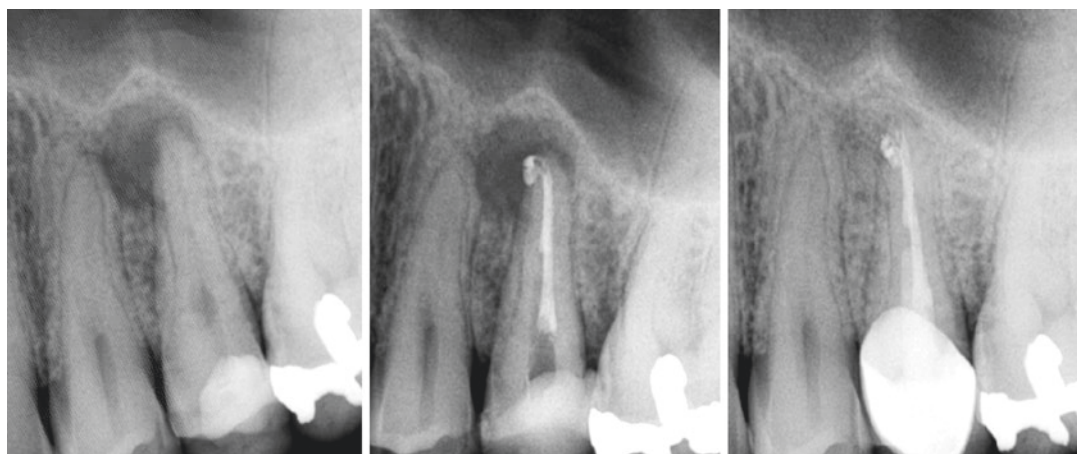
Second maxillary premolar—the patient presented with a sensitivity to percussion: preoperative radiograph—extensive coronal restoration and radiolucent
